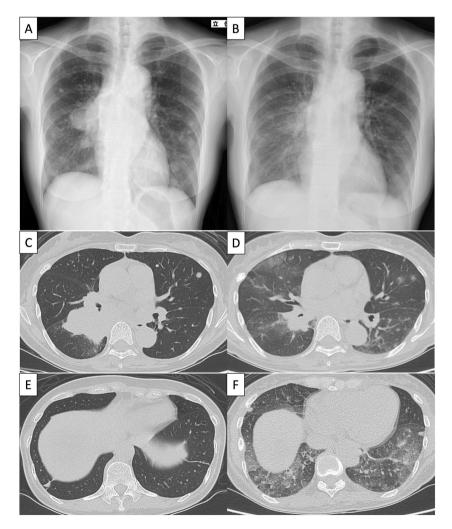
A chest radiograph showing a mass shadow in the right pulmonary hilum and multiple nodular shadows predominantly in both lower lung fields on initial examination (A) These shadows became smaller one month of treatment with osimertinib and ground-glass opacities appeared in the bilateral lower lung fields (B). Computed tomography of the chest confirms shrinkage of the primary and metastatic sites of cancer. It also reveals the presence of diffuse ground-glass opacities with interlobular septal thickening in the lower lobes dominant one month after the administration of osimertinib (C–F).
